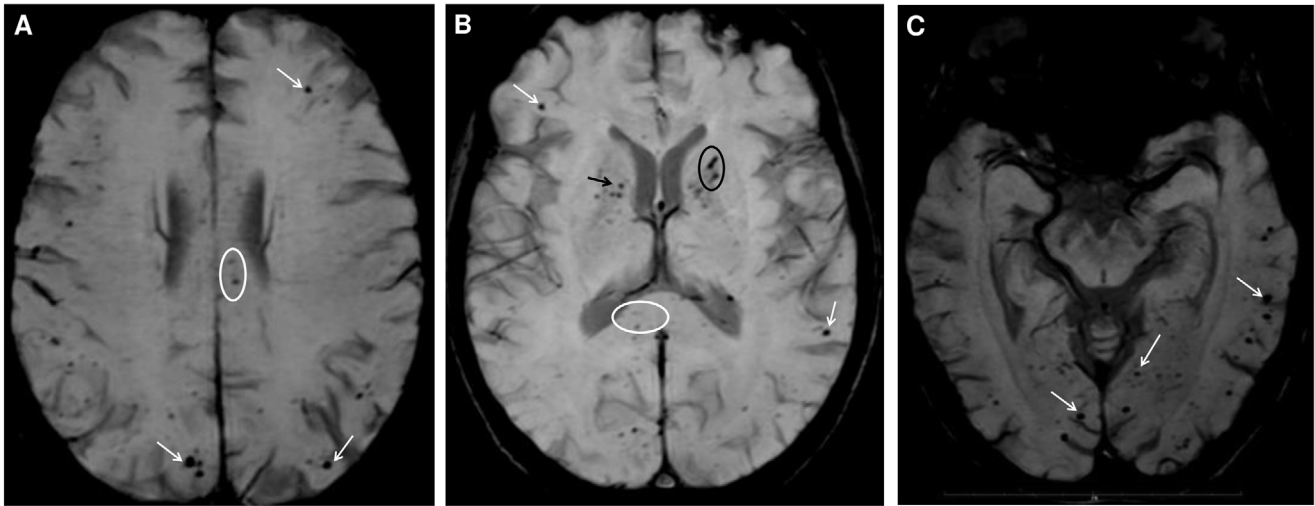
Multiple hypoattenuating foci involving the subcortical white matter (white arrows in A-C), as well as the corpus callosum (white ellipse in A and B), the anterior limb of the internal capsule (black arrow in B) and both middle cerebellar peduncles (not shown here), observed in susceptibility weighted imaging of the brain MRI of a 56-year-old woman. Interestingly, some of the lesions present a more linear shape, opening a differential diagnosis of microthrombi within vessels (black ellipse in B).
